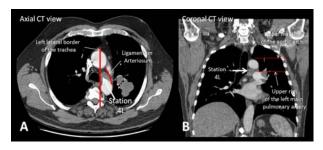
A. Axial CT view reveals the left upper lobe mass and the 1.5 cm left paratracheal lymph node (station 4L) between the left lateral border of the trachea and ligamentum arteriosum.
